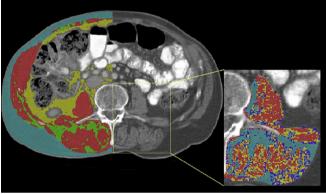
Two cancer patients with different mean muscle attenuation and intermuscular adipose tissue. Main panels: Total lumbar CT images (at 3rd lumbar Hounsfield Units (HU); visceral adipose tissue, VAT, −150 to −50 HU; subcutaneous adipose tissue, SAT, ■ –190 to –30 HU; inter-muscular adipose tissue, IMAT, = -190 to -30 HU. Insets: Psoas and paraspinal muscles: attenuation ranges used for normal attenuation SM, = +30 to +150 HU; and abnormal (reduced) attenuation muscle in two range [65]: [■ -29 to 0HU; - +1 to +29HU] and IMAT, --190 to -30 HU. Patient in upper panel represents a typical (median) individual: male, BMI 22.5 kg/m², aged 69 v with sigmoid colon adenocarcinoma stage III. Overall SM = 164.9 cm^2 with mean attenuation 34.9 HU; VAT = 319.7 cm^2 ; SAT = 78.0 cm^2 and IMAT = 8.2 cm². Psoas and paraspinal normal muscle (inset) 65% of area is between +30 and +150 HU. Patient in lower panel has extensive fatty infiltration and extensive areas of abnormal attenuation: male, BMI 22.5 kg/m², aged 69 v with metastatic gastroadenocarcinoma. Overall: SM = 129.5 cm² with mean attenuation 23.3 HU; VAT = 58.7 cm²; SAT = 114.0 cm²; IMAT = 38.9 cm². Psoas and paraspinal normal muscle (inset) 34% of area is between +30 and +150 HU and remaining area is in abnormally low attenuation ranges between -29 and +29 HU. Neither patient had a history of diabetes or neuromuscular diseases.
